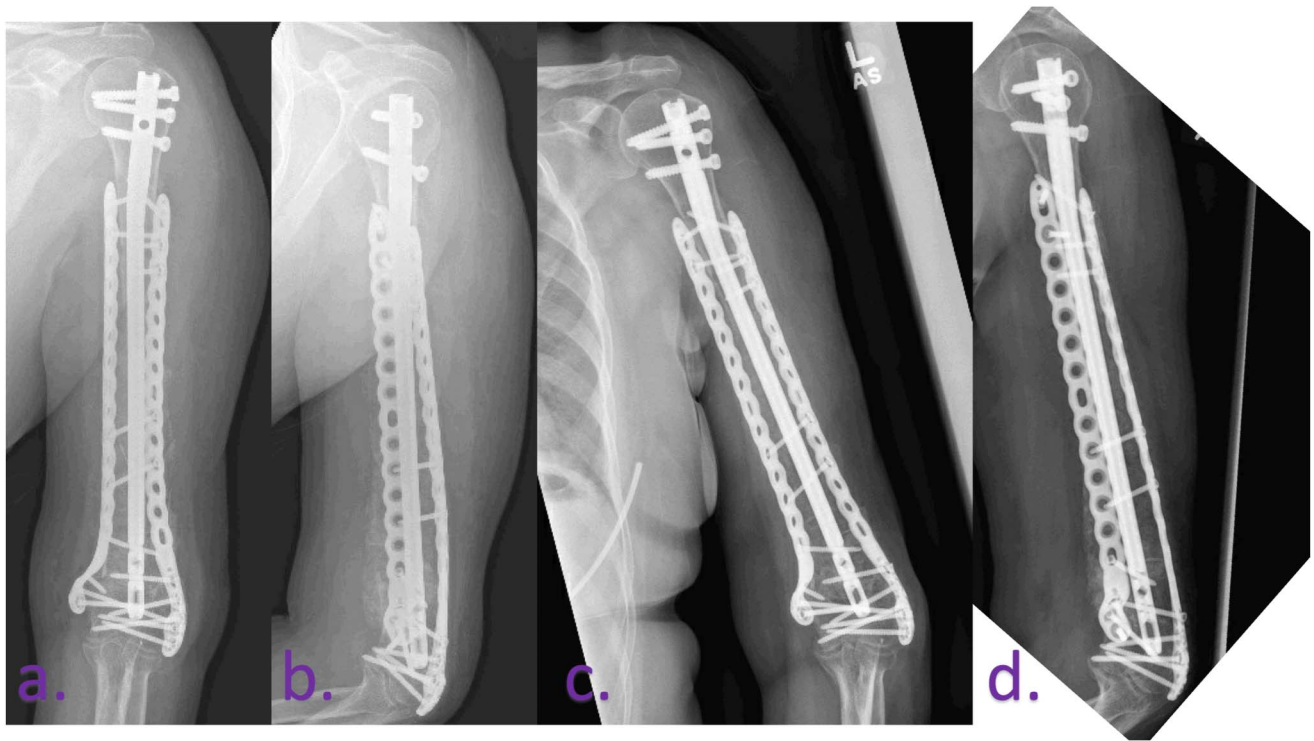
Postoperative radiographs after second stage Masquelet. Six weeks postoperative second stage Masquelet AP (A) and lateral (B) plain radiographs. Three months postoperative second stage Masquelet AP (C) and lateral (D) plain radiographs.
